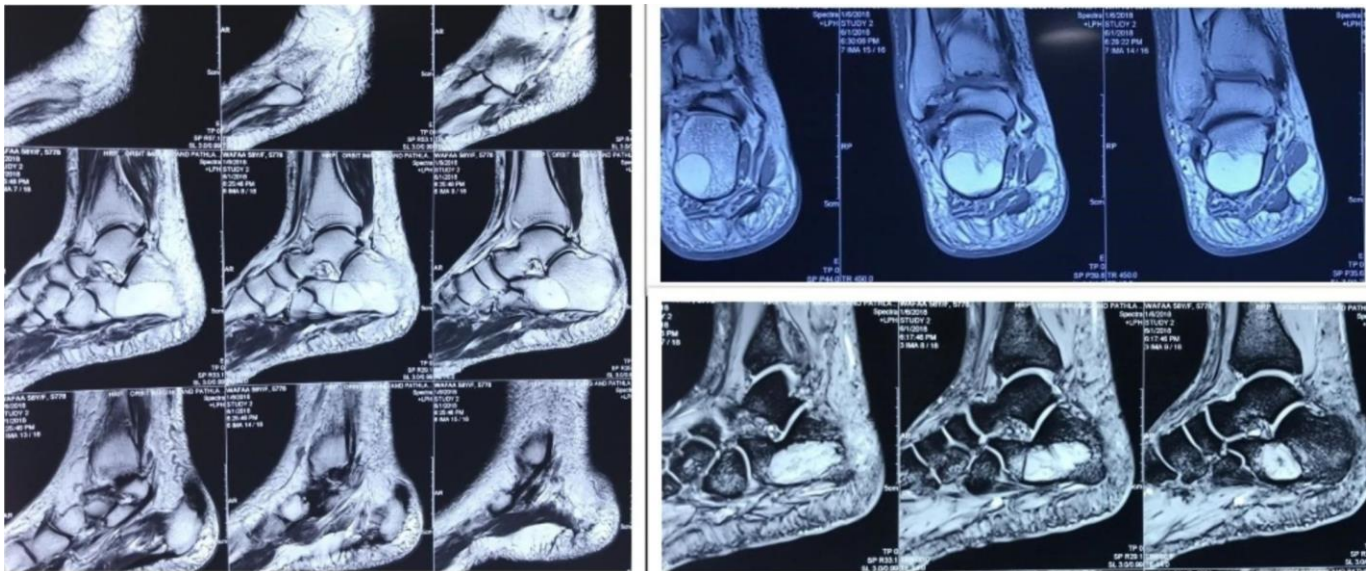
MRI images showing a well-defined T1/T2 hyperintense lesion in the anterior and mid part of the calcaneus with suppression on STIR images
